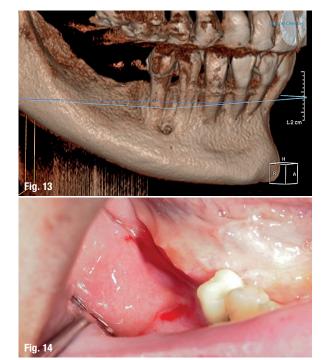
CBCT reconstruction of a deficient ridge in the lateral mandible. Fig. 14: Preoperative intraoral finding in the atrophic posterior mandible.
